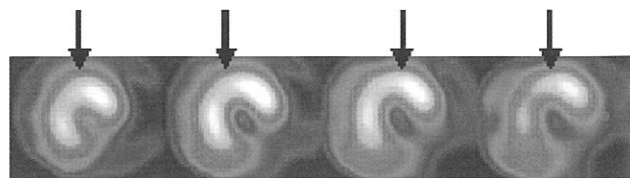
^{18}F -FDG metabolism images
